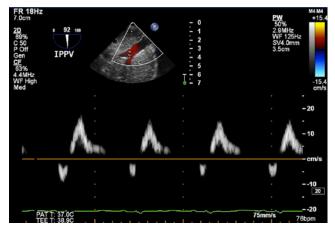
The same patient as in figure 9. This still continuous wave Doppler (CWD) image demonstrates impaired venous return velocities and cyclic episodes of flow reversal.
